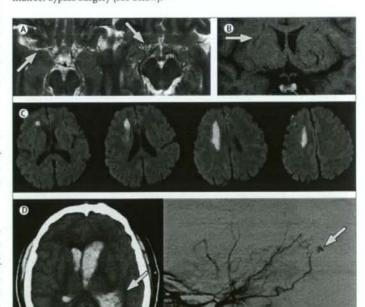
Typical findings of moyamoya disease seen with MRI and CT
